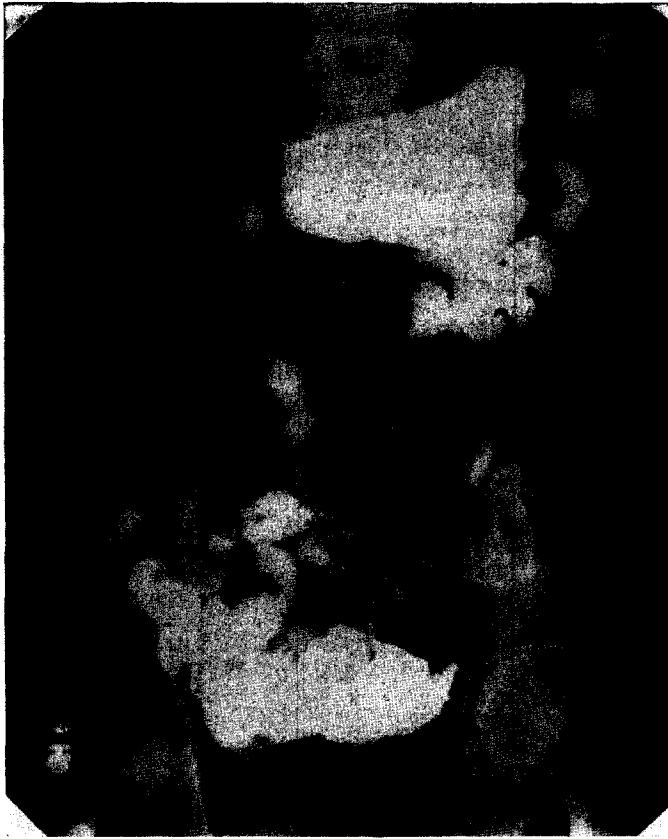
Case XI. Roentgenogram taken four hours after that shown in Figure 1. Most of the barium in the small bowel has now passed into its distal loops. There is still barium present in the transverse colon at the point of communication with the stomach.
